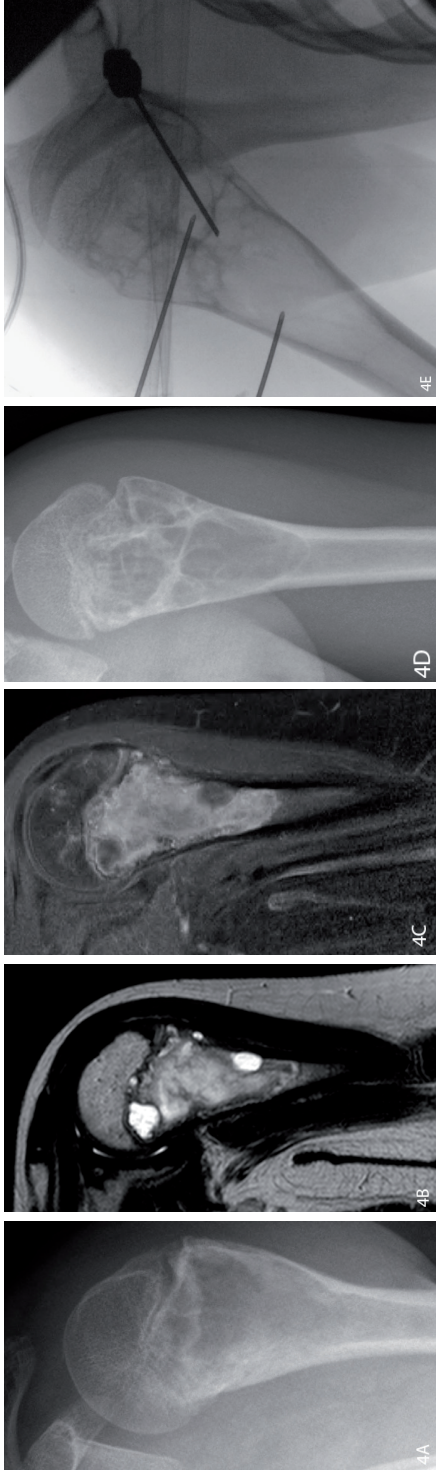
Cystic embolization in fibrous dysplasia of the humerus. Patient nr. 40 presented with a pathologic fracture of the humerus after a minor trauma. Radiographs showed an osteolytic lesion of the diaphysis and metaphysis with cortical thinning (4A). Sagittal MR imaging showed a lesion with intermediate signal intensity on T1-weighted images (4B) in combination with focal islands with high intensity, a high signal on coronal T2-weighted images and inhomogeneous signalling after administration of contrast (4C). A diagnosis of fibrous dysplasia with cystic degeneration was made. Two years later further cortical thinning indicative of an impending fracture was seen on conventional radiographs, (4D). This was treated with an injection of aethoxysclerol in order to prevent recurrent fractures (4E and F) resulting in complete relief from pain, free range of motion of the upper arm and good mineralisation of bone on a control radiograph 1 year after treatment (4H).
